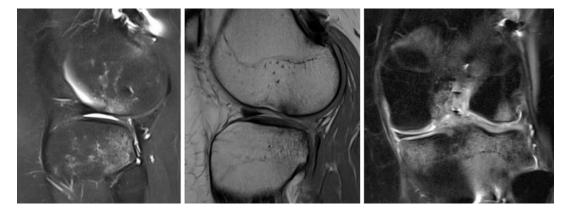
MRI demonstrated lateral meniscal deficiency and a disrupted ACL graft
